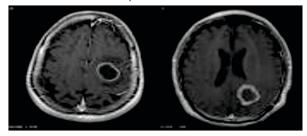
1 Single nodular ring enhancing lesion on contrast enhanced CT scan.
